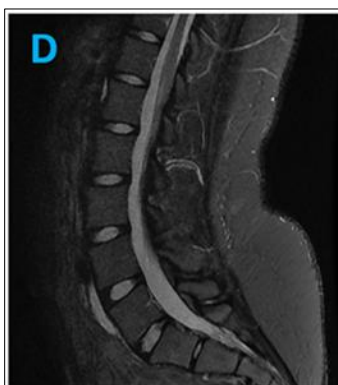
Magnetic resonance imaging (MRI) with/without IV contrast of the spinal cord: showed no abnormalities in the spine including normal height and appearance of the vertebral bodies & intervertebral discs, no evidence of soft tissue edema or disc herniation, no evidence of spinal or foraminal stenosis, no epidural collection or areas of abnormal enhancement on postcontrast images
